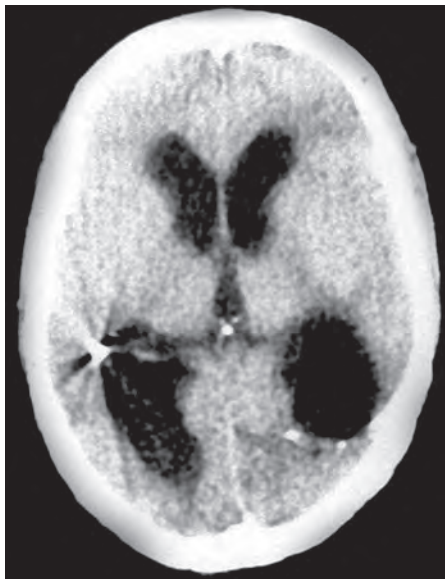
CT brain showing intraventricular splinter with hydrocephalus
